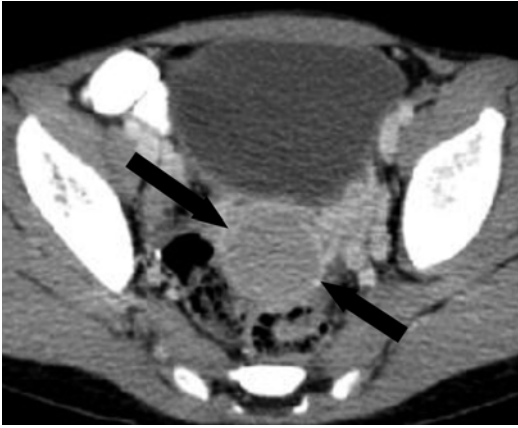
Transaxial section from a contrast-enhanced CT scan in a 6-year-old with Wilms tumor demonstrates a pelvis drop metastasis (arrows)
